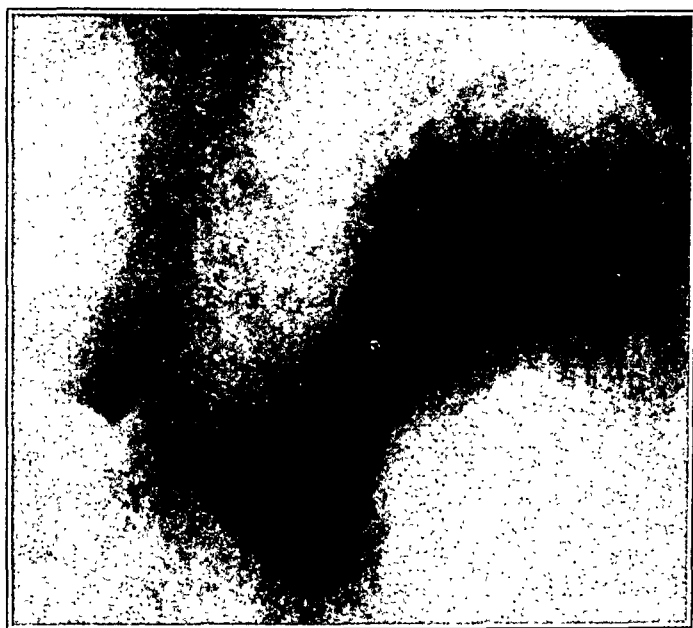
Roentgen-ray photograph of stomach of B. D. after barium. Defect seen on greater curvature, caused by pressure of the pancreatic cyst.
